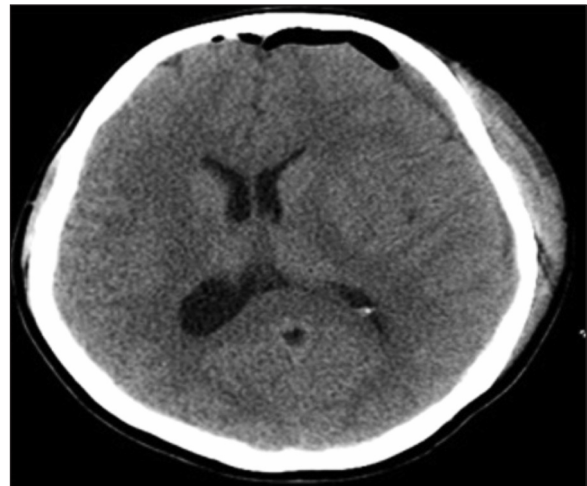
CCT scan showing regression of bleeding and shift on CT scan on post-operative day 1. The air seen in the radiograph is secondary to the craniotomy.
